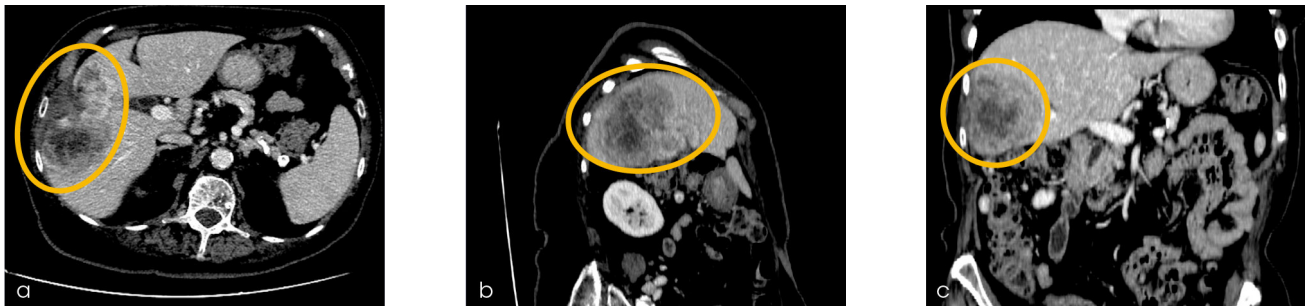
Abdominal follow-up CT before DSM-TACE showing disease progression
